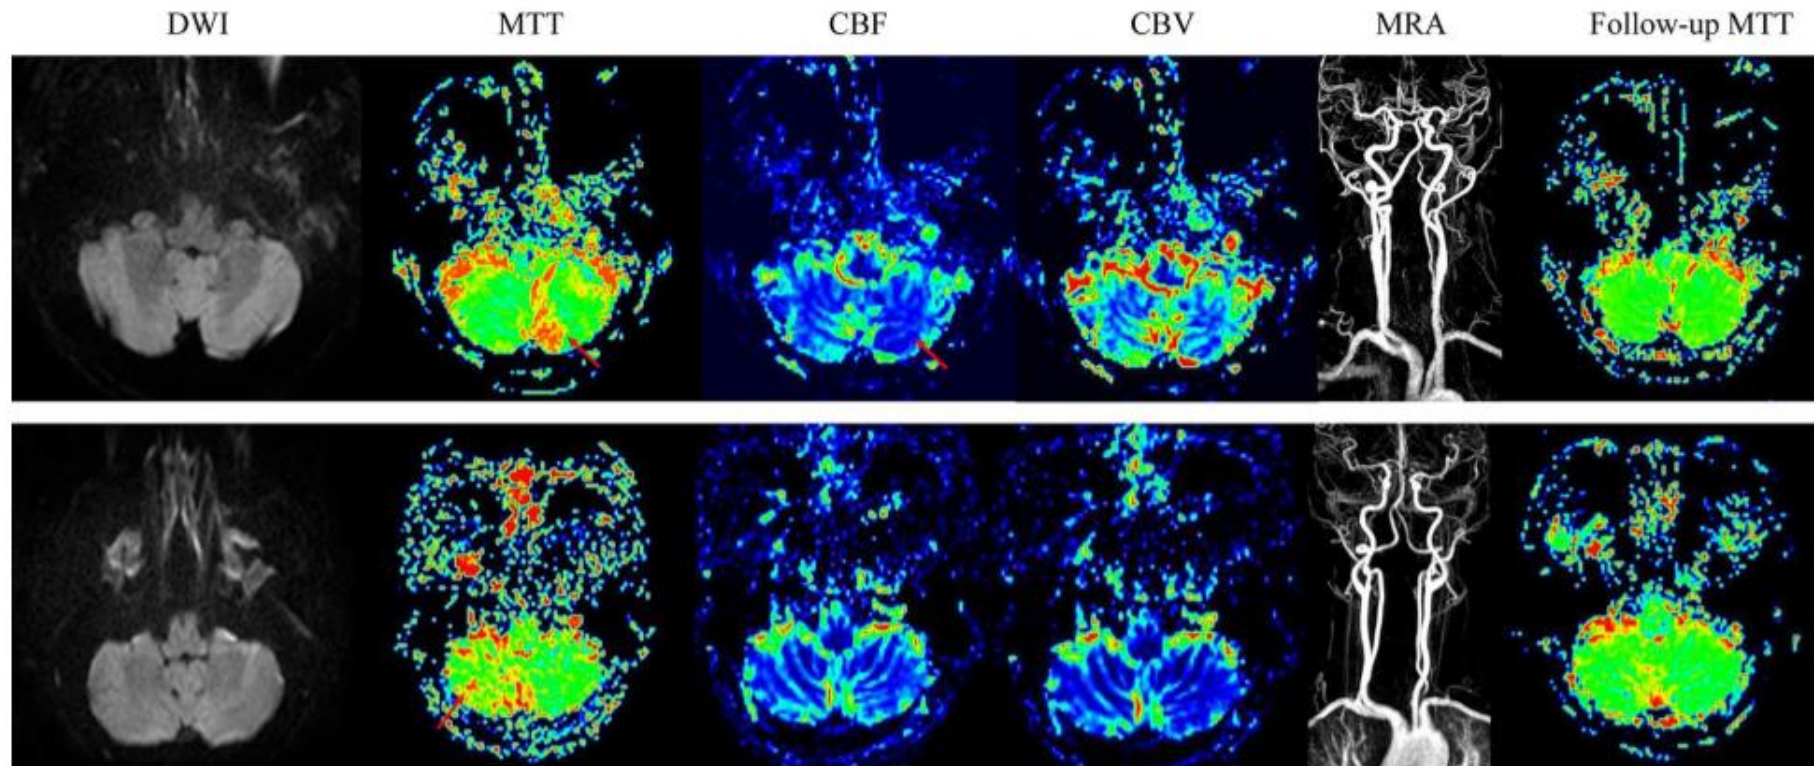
Diffusion-weighted image (DWI, first panel), MR angiography (MRA, fifth panel), and initial (second, third, and fourth panels) and follow-up perfusion-weighted images (PWI, sixth panel) in 2 patients with acute transient vestibular syndrome due to cerebellar hypoperfusion. In the first patient, the initial PWIs reveal a prolonged mean transit time (MTT) and a reduced cerebral blood flow (CBF) in the left medial cerebellum without a diffusion restriction and cerebral
